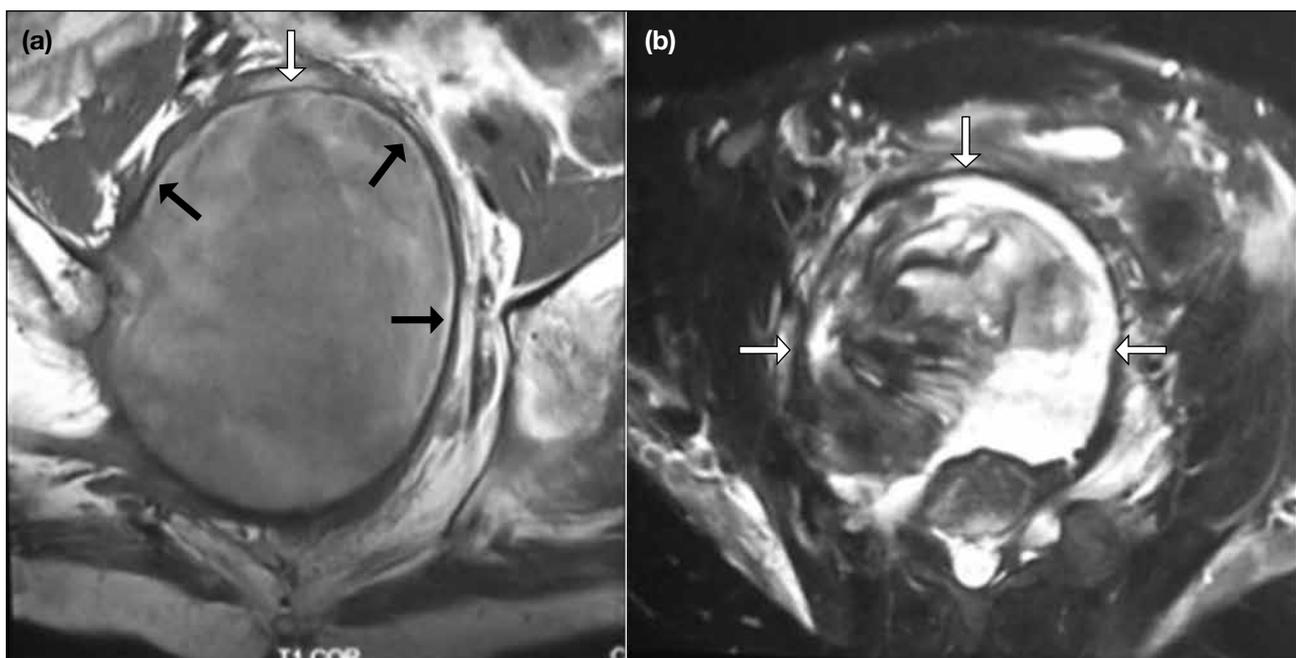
Magnetic resonance imaging: (a) coronal T1-weighted and (b) axial fat-suppressed T2-weighted images of a large pelvic lesion with well-defined hypointense rim (white arrows) and mixed signal intensity within the lesion. The hyperintense inner rim (black arrows) is well demonstrated on T1-weighted images.
